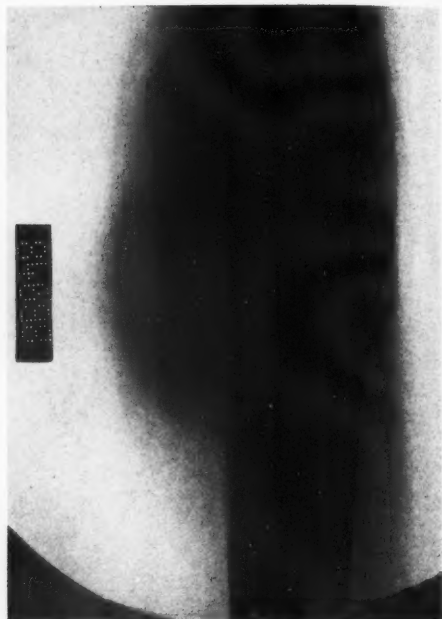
Roentgenogram of a giant-cell tumor showing the epiphyseal location of the lesion, the asymmetrical expansion of the cortex, and the bone-destructive character of the growth.
